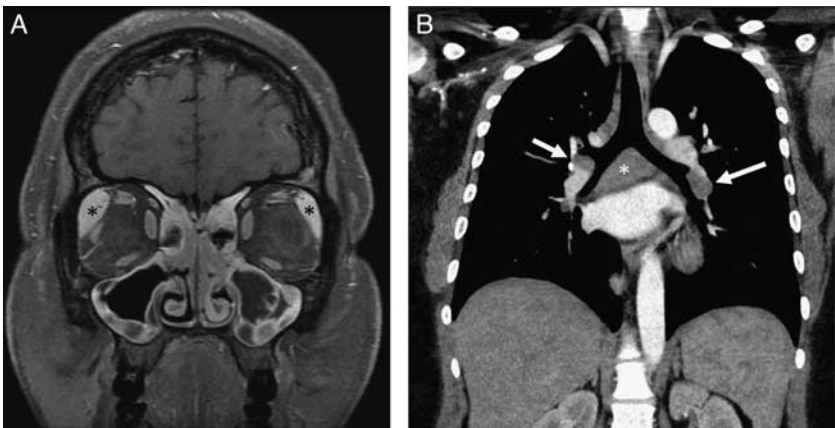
29-year-old African American female was referred to ophthalmology for right eye redness and ultimately underwent right lacrimal gland biopsy demonstrating sarcoid. Coronal T1-weighted postcontrast fat-saturated magnetic resonance imaging demonstrates hyperenhancing, enlarged bilateral lacrimal glands (A, black asterisks). Coronal contrast-enhanced computed tomography demonstrates hilar (white arrows) and mediastinal (white asterisk) lymphadenopathy suggestive of sarcoid (B).
